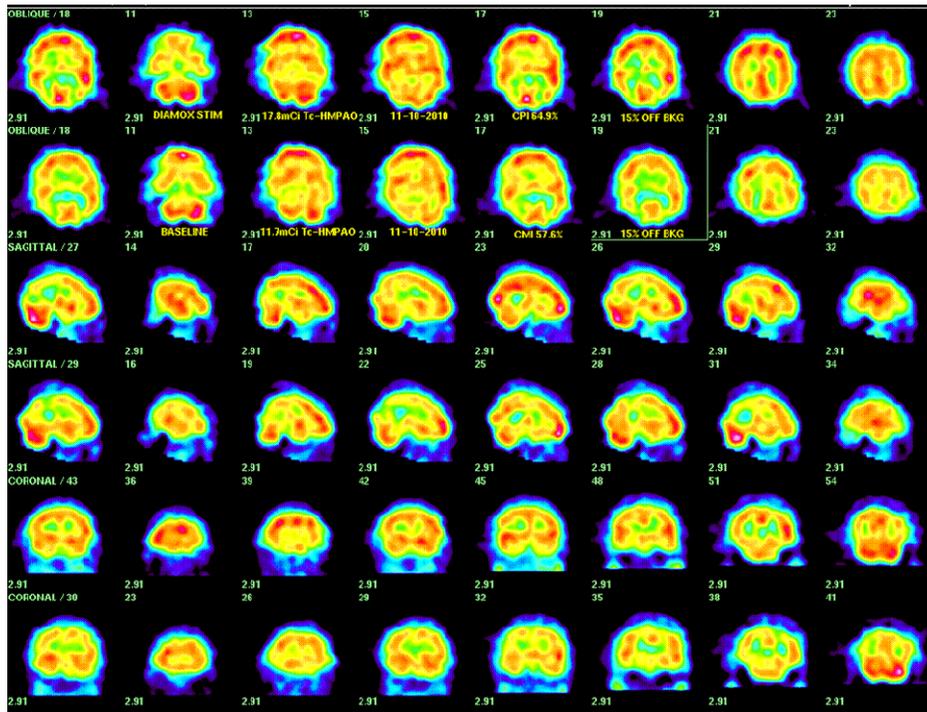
(above) To the right are brain SPECT images, acetazolamide (Diamox) 500 mg IV stimulated, shown in the top of three paired rows of images, over basal images, shown on the bottom of three paired rows of images. The patient is a 56 year-old African American woman post subtotal thyroidectomy for multinodular goiter, euthyroid on replacement l-thyroxine and with menopausal symptoms treated by estradiol. Her CMi 57.7% and CPI 64.9% are within normal limits ($56.6 \pm 12.9\%$) for CMi and ($67.7 \pm 13.4\%$) for CPI among 34 patients with low likelihood of disease. Clinical complaints among these patients included migraine headache, patients with minor depression and a practicing physician with concern about possible minor memory impairment. No neurologic events were observed in these patients with an average follow-up of at least two years and several of them had repeat scans demonstrating stable or improving cortical indices. Repeated evaluations without intervening therapy or neurological clinical events typically were within a standard error of 3% in individual patients. The standard error of recalculation of CMi and CPI by trained technologists is $< 0.5\%$.
